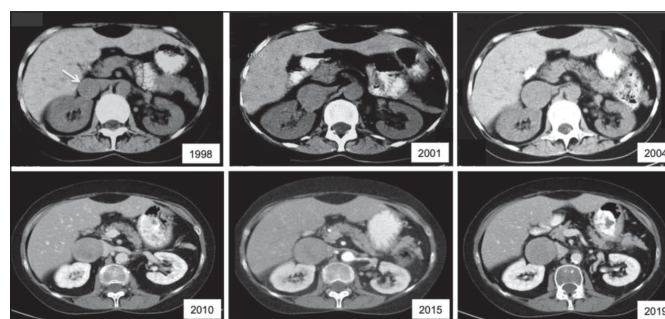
Abdominal CT scan showing the partially resected right pheochromocytoma.
